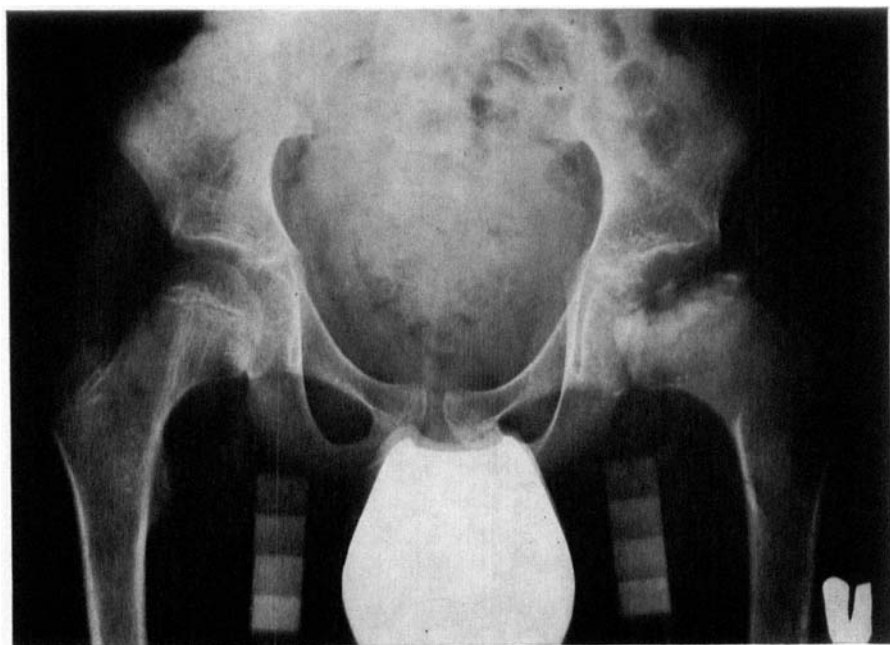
Radiograph of the hips corresponding to Figure 5.
